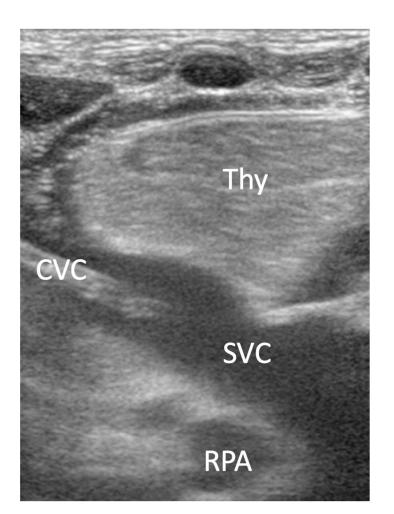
Parasternal craniocaudal view: thymus (Thy), central venous catheter (CVC), superior venae cava (SVC), right pulmonary artery (RPA).
